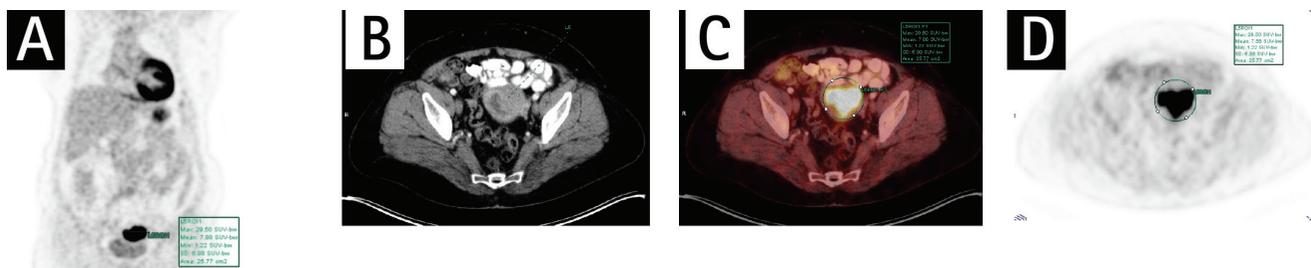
Maximum standardized uptake value of the primary tumor was measured 29,50. Endometrioid type endometrial carcinoma (grade 1, International Federation of Gynecology and Obstetrics stage 2). A) Maximum intensity projection image. B) Transaxial computed tomography image. C) Transaxial positron emission tomography+computed tomography fusion image. D) Transaxial positron emission tomography image of the primary tumor
